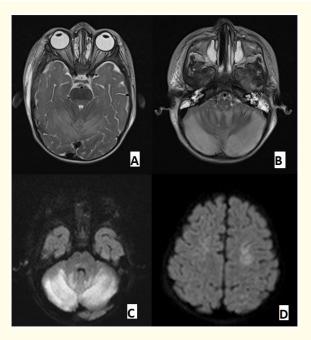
MRI in T2 sequence in axial section (A, B), and axial diffusion (C, D) showed high intensity signal with restrictive diffusion of bilateral and slightly asymmetrical cortico-subcortical areas of the cerebellar hemispheres, cerebellar peduncles, posterior part of the Pons, and some frontal and parietal gyrus related to anoxo-ischemic lesions.
